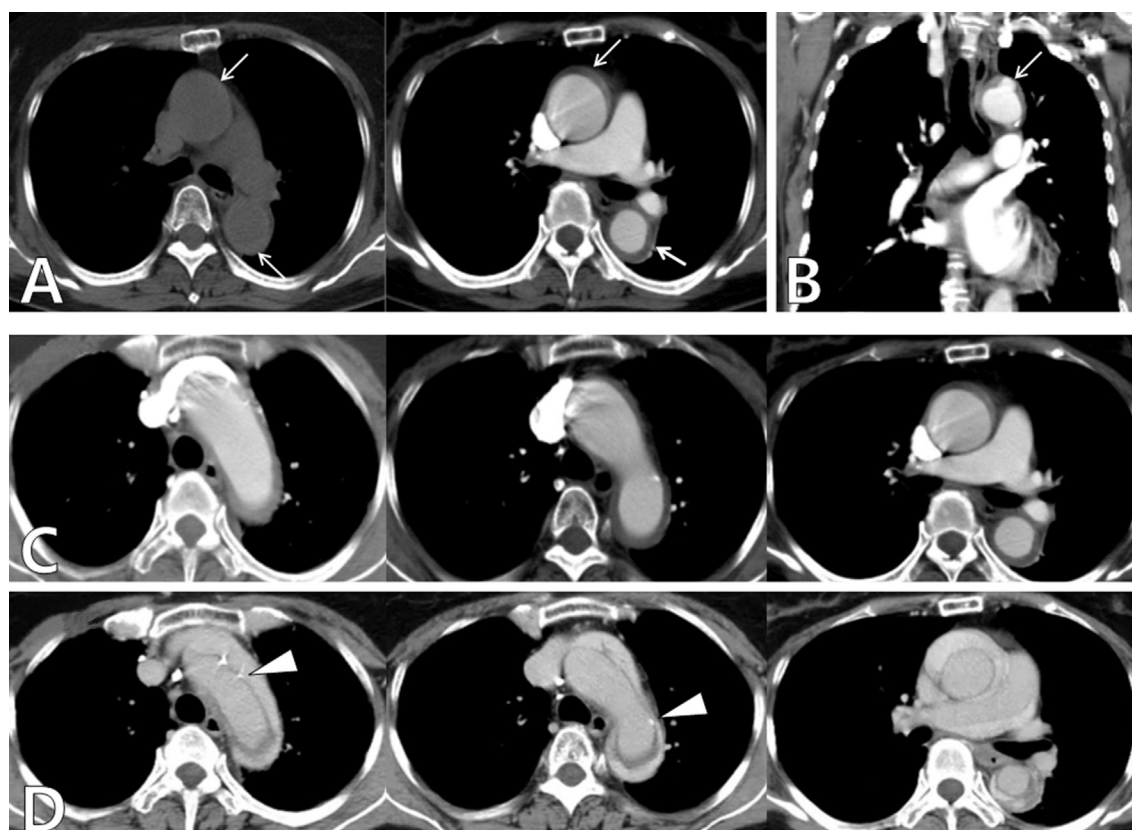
Progression of intramural hematoma to overt aortic dissection between arterial- and delayed-phase CT scan. (A) Evidence of proximal intramural hematoma. On precontrast CT, the arrows indicate continuous high-attenuation thickening of the aortic wall secondary to intramural hematoma. On arterial-phase CT, the arrows indicate less conspicuous intramural hematoma against contrast-enhanced aortic lumen; (B) on arterial-phase CT, the arrow indicates an ulcer-like projection 1 cm distal to the origin of the left subclavian artery; (C) arterial-phase CT demonstrates intramural hematoma involving the ascending aorta, aortic arch, and descending thoracic aorta; and (D) on delayed-phase CT, the arrowheads indicate calcifications within intimo-medial flap of aortic dissection. CT = computed tomography.
